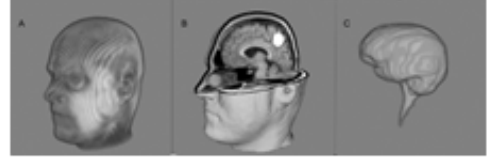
(A) A three dimensional rendering of a set of T1 weighted MRI slices of a real human head. (B) An initial fictitious virtual spherical glioblastoma tumor of radius equal to 1.4 cm (denoted by white color) lying inside the skull cavity. (C) Reconstruction of the brain cavity of the skull following segmentation of each MRI slice.
